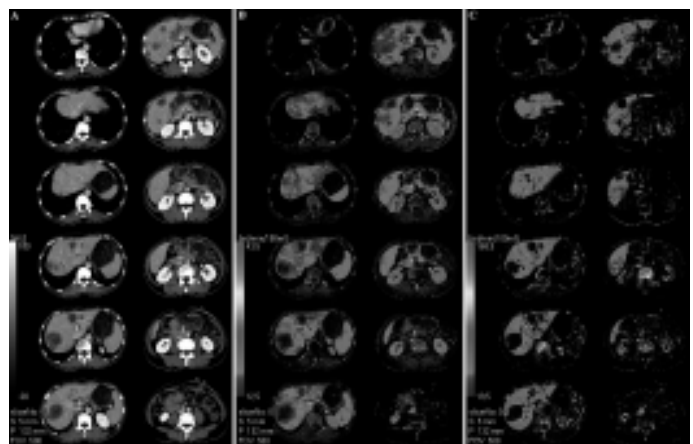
Total liver volume perfusion CT
